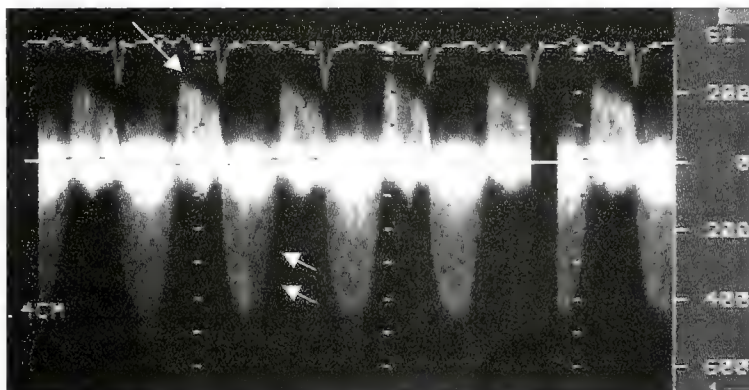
Continuous wave Doppler echocardiogram demonstrating peak flow of 5.4 m/sec (paired arrows) across the right ventricular outflow tract. A dense Doppler envelope is seen in both systole (paired arrows) and diastole (single arrow) consistent with severe outflow obstruction and pulmonic regurgitation.
